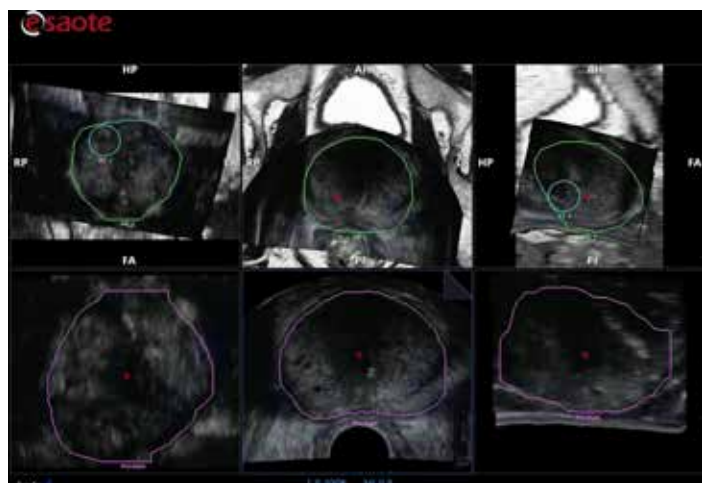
Superimposition of the 3D US volume with the MRI findings, during automatic synchronization.
